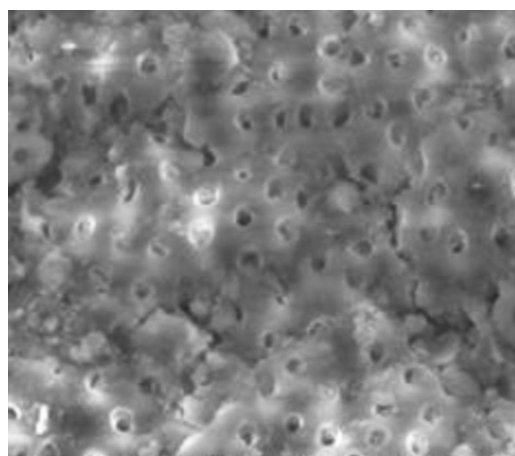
Ultrasonic group cervical level (score 1)
